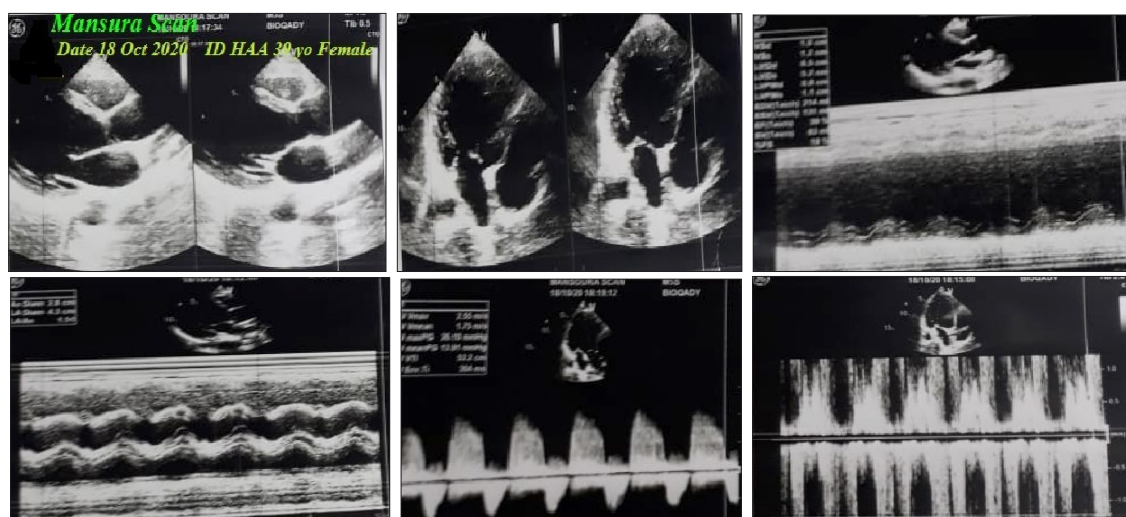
The initial echocardiography was done within 2 days of preoperative aortic valve replacement showing thickened aortic cusps with severe aortic regurgitation (grade III/IV AR, peak/systolic gradient 26/13 mmHg, and aortic annulus 2.3cm), thickened both mitral leaflets, especially at tips with characteristic doming with mild MR (grade I-II/IV MR), dilated left atrium, dilated left ventricle with EF of 39%, and diastolic dysfunction with reversed E/A%.
